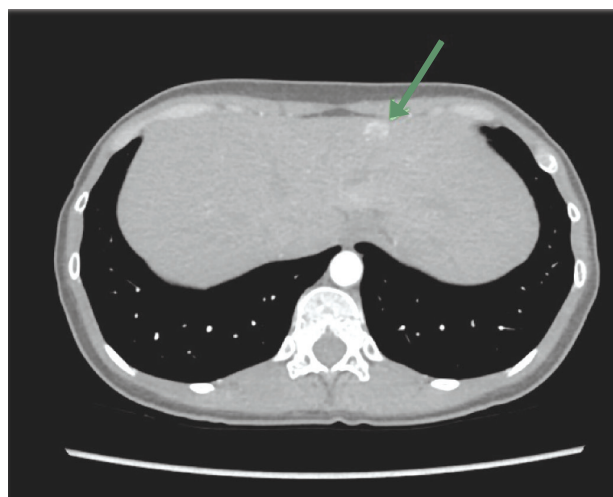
Contrast CT scan shows the mass size 1.5 cm. at segment 3 (S3) in the arterial phase.
